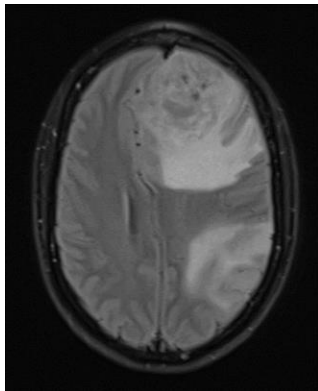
Axial T2\* Relaxed Gradient Echo FLAIR
